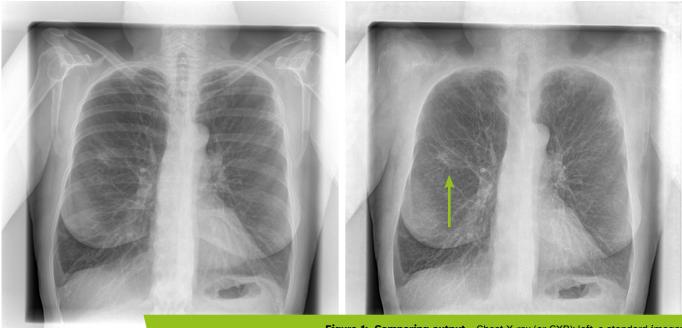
Comparing output – Chest X-ray (or CXR): left, a standard image; right, the same image post-processed using the Bone Suppression algorithm.
